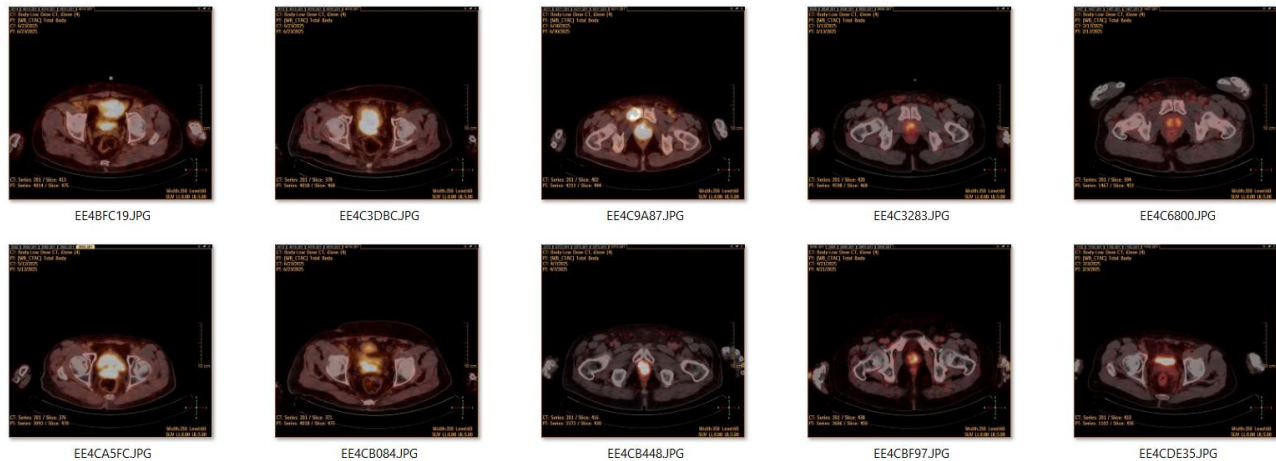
Sample PET/CT cuts from the dataset, showing variations in cancer appearance
